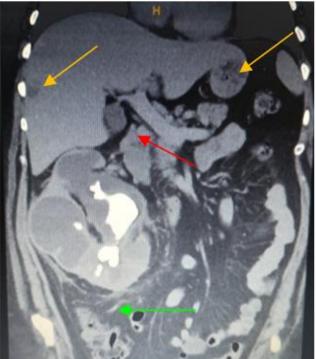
Abdominopelvic CT scan with intravenous contrast staghorn calculus in the RK, significant pelvicalyceal dilation. Inflammatory changes in the perirenal fat (green arrows). A portocaval adenopathy conglomerate (red arrow). Hypoenhancing hepatic lesions (yellow arrows).
